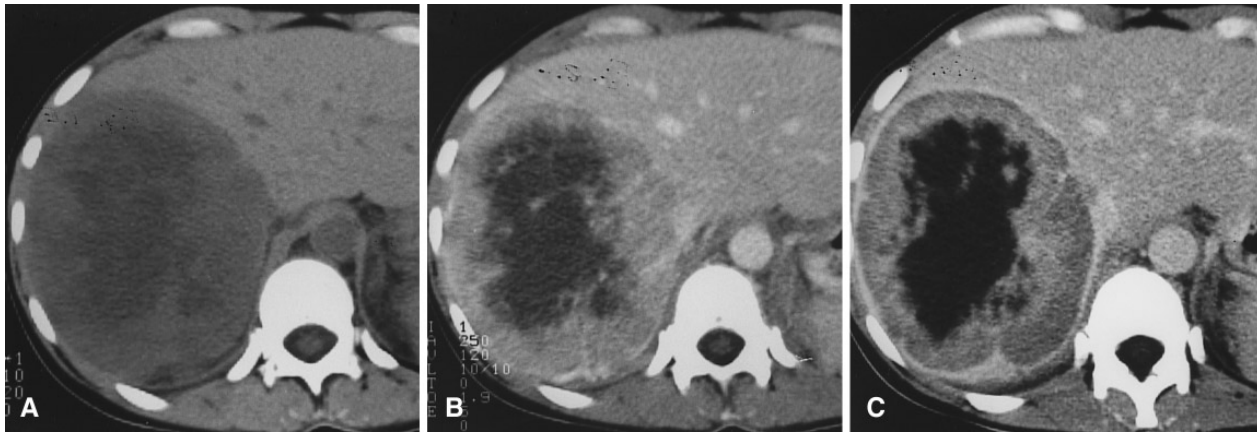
Case 2. A Unenhanced CT scan of the liver shows a large mass of the right hepatic lobe, heterogeneously hypodense, with well-defined regular contours. B After iodinated contrast-medium administration, definite contrast enhancement of the tumoral solid portion is
